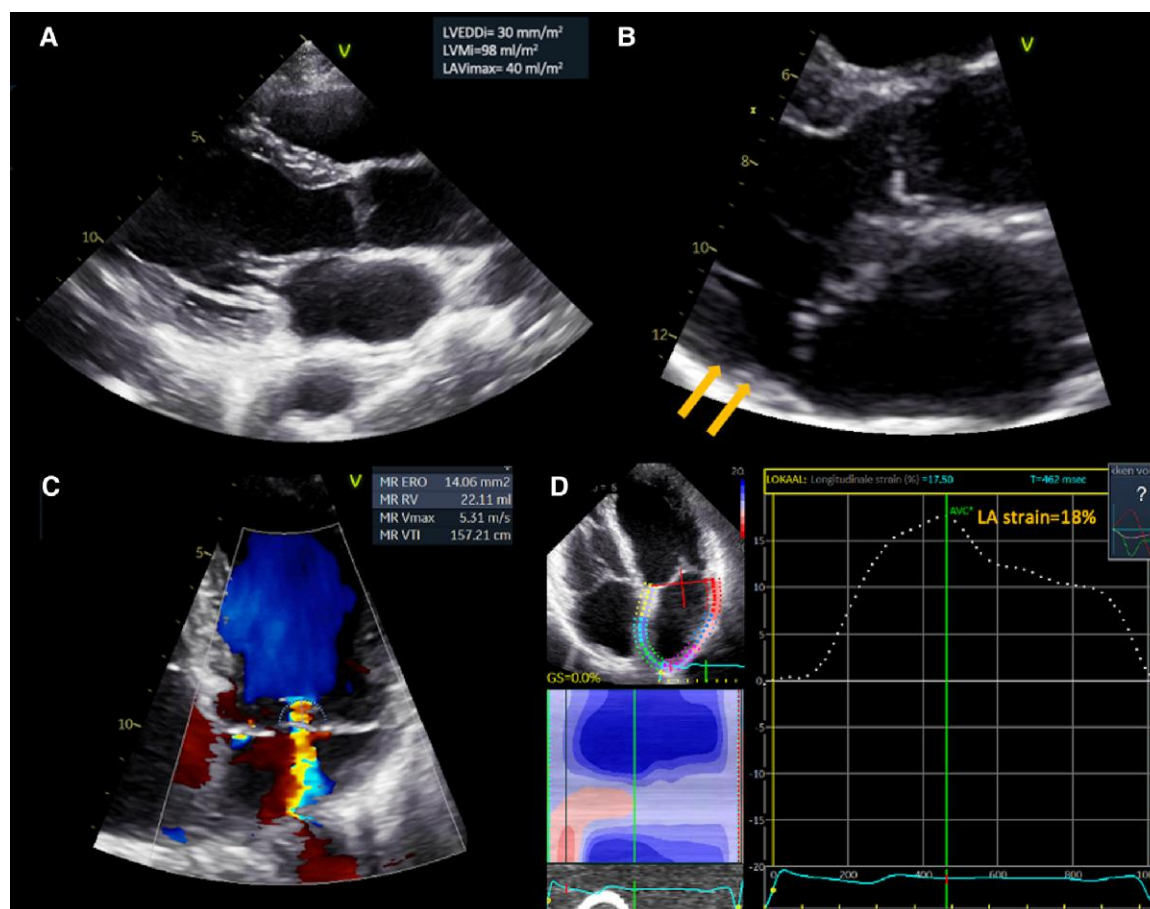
Example of echocardiographic measurements in a BD patient. (A, B) Images from a 37-year-old woman with BD and bileaflet MVP are shown. She presented a mild LV and LA dilatation, with eLVH. A MAD is also evident (indicated by arrows). (C) MR was graded as mild MR (EROA 14 mm²), with an end-systolic, central jet. (D) Speckle-tracking analysis revealed an impairment of LA reservoir strain. BD, Barlow's disease; EROA, effective regurgitant orifice area; LA, left atrial; LV, left ventricular; eLVH, eccentric LV hypertrophy; MAD, mitral annular disjunction; MR, mitral regurgitation; MVP, mitral valve prolapse.
